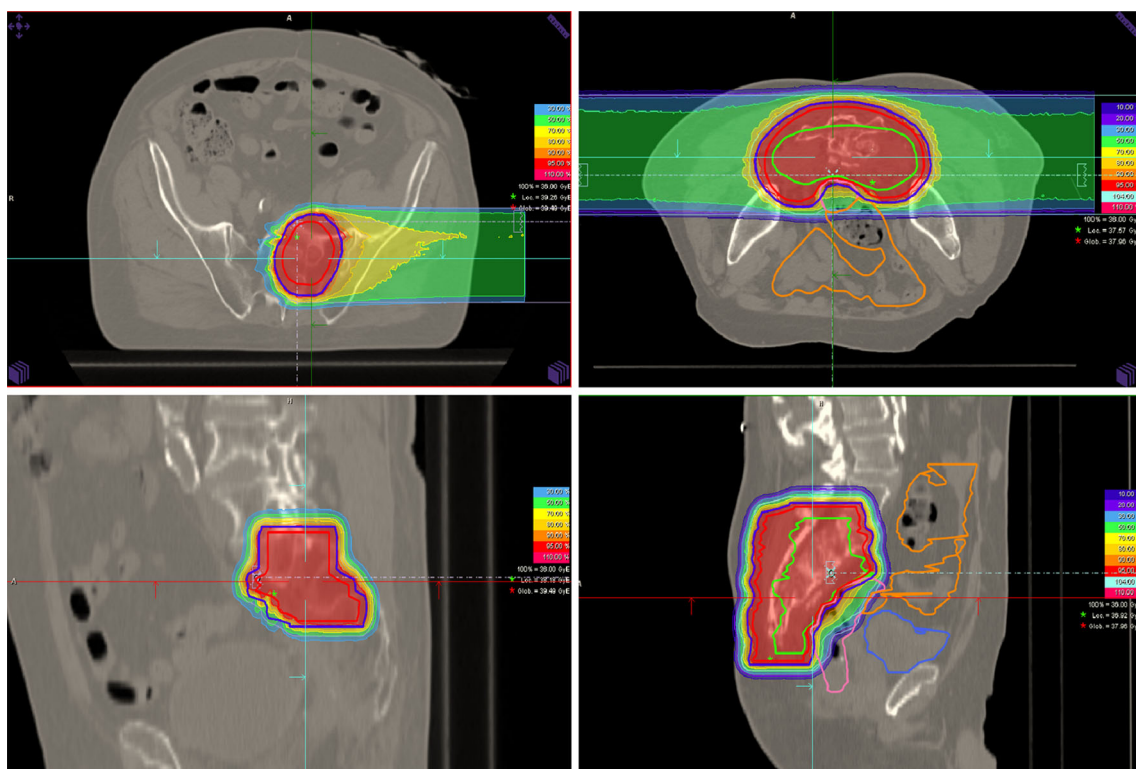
Example of single-beam ¹²C treatment plan (*left*) demonstrating dose distribution in axial (*top left*) and sagittal (*bottom left*) CT slices. Example of a 2-opposed beam plan demonstrating dose distribution in axial (*top right*) and sagittal (*bottom right*) direction
